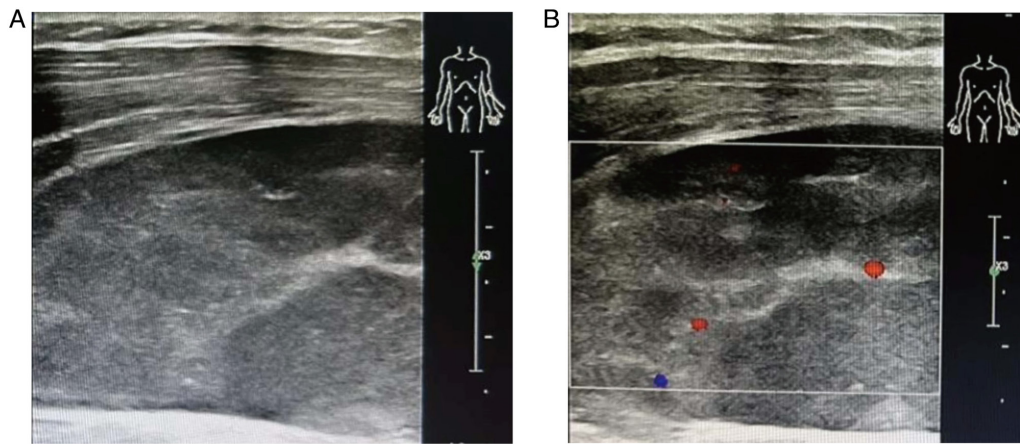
Ultrasound imaging after trauma to the forearm (January 2024). (A) Color Doppler imaging shows a spindled hypoechoic mass with a regular shape and a clear boundary in the left brachioradialis and supinator muscles, and (B) color Doppler flow imaging shows a spot blood flow signal around the mass.
